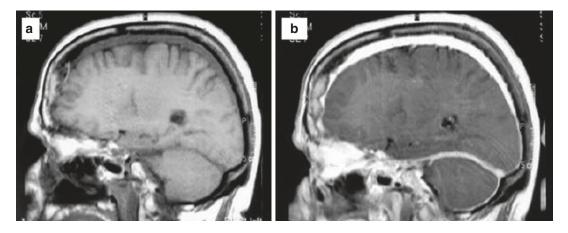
T1-weighted pre-gadolinium (a) and post-gadolinium (b) sagittal MRI sections showing diffuse pachymeningitis (From D'Andrea et al. [22] with permission)
